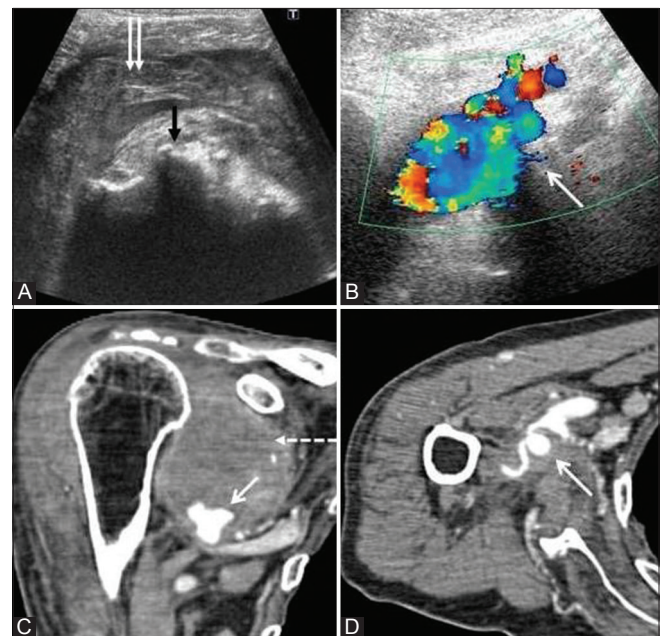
(A-D): (A) B mode ultrasound shows thickened and hypoechoic synovium (paired arrows). Extrinsic erosions (black arrow) are seen in the humeral head with moderate joint effusion. (B) The pseudoaneurysm in the inferior axillary region shows bidirectional flow (arrow) on color Doppler study. (C-D) CT angiography shows pseudoaneurysm (arrow) communicating with axillary artery. The thrombosed portion of aneurysm (interrupted arrow) is appearing as hyperdense soft tissue lesion around the contrast-filled patent aneurysmal sac (arrow)
